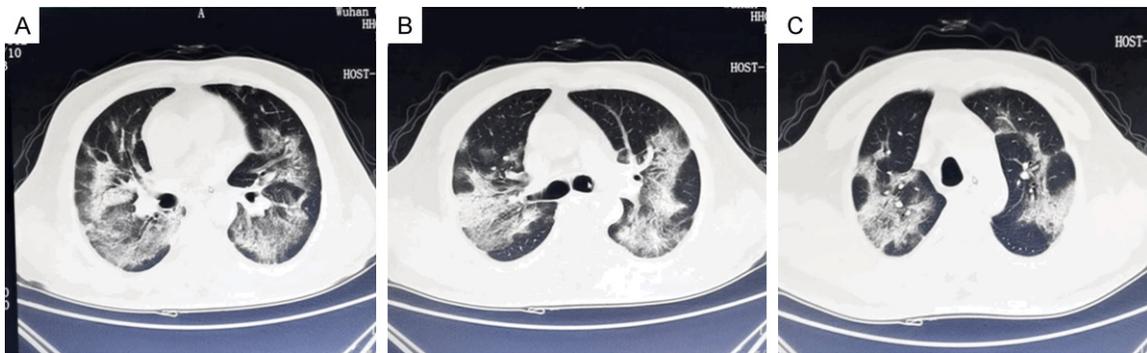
Chest CT scan from a 68-year-old COVID-19 male case complicated with T2D, showing fever and cough for ten days, and chest pain and shortness while breathing for five days. A. The first level. B. The second level. C. The third level.
